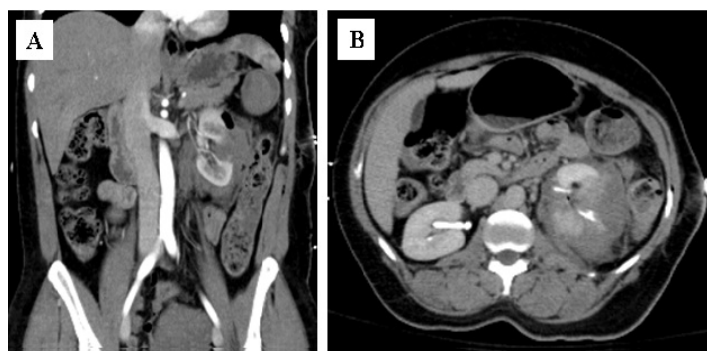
Initial Trauma CT. A) Coronal view, B) Axial view.
